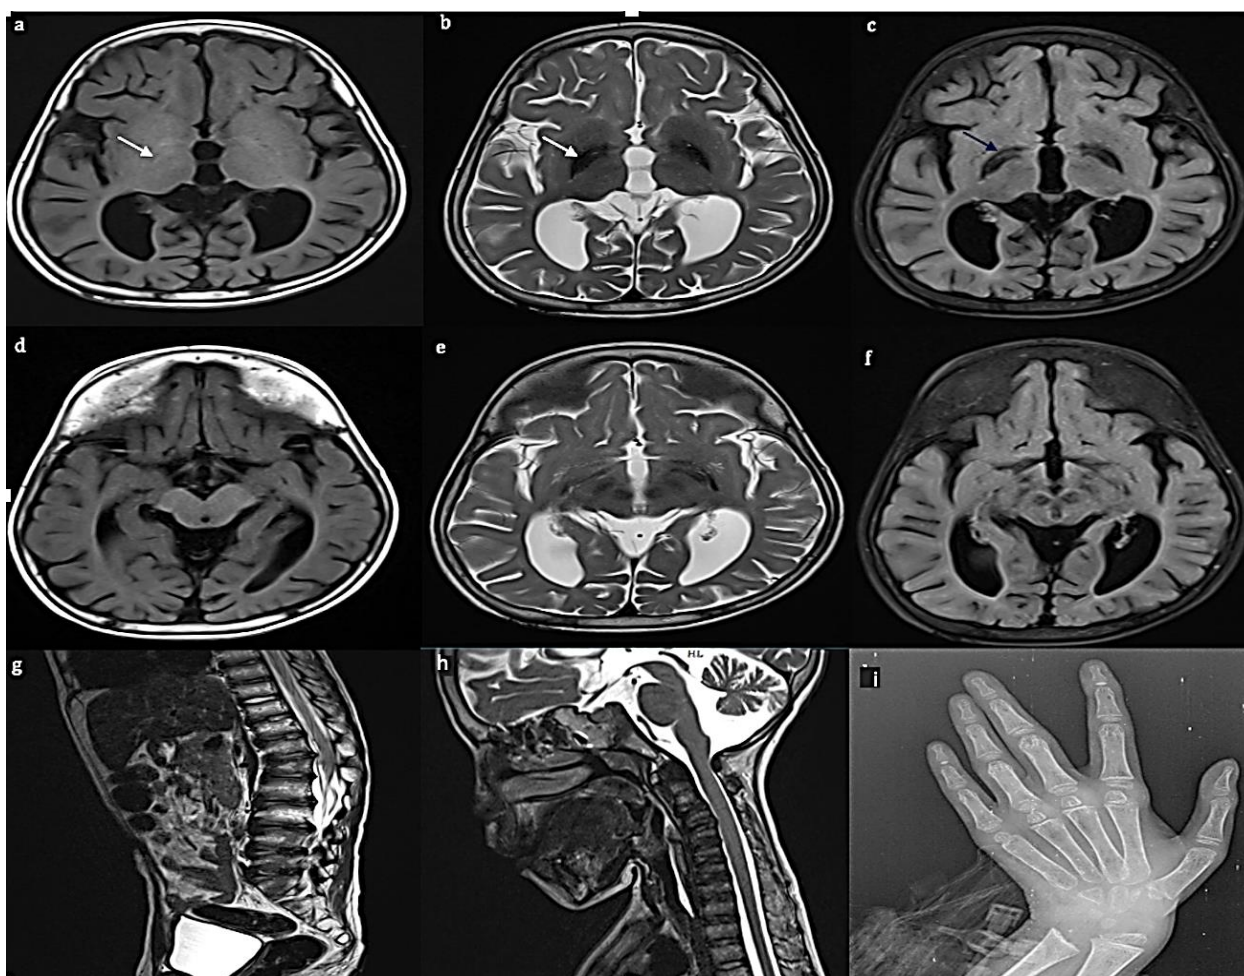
Axial brain T1 magnetic resonance imaging (MRI) (a), T2 (b), and fluid-attenuated inversion recovery (FLAIR) (c) images at the level of basal ganglia showing bilateral globus pallidus appearing hyperintense on T1-weighted imaging (T1WI), markedly hypointense on T2-weighted imaging (T2WI) (marked by white arrow) and FLAIR. There is curvilinear hyperintensity within basal ganglia on T2 and FLAIR images (marked by blue arrow). There is associated prominence of cortical sulci and ventricles which represents generalized cerebral atrophy; axial brain T1 MRI (d), T2 (e), and FLAIR (f) images at the level of mid brain showing substantia nigra and red nuclei appearing hypointense on T2WI and FLAIR (marked by white arrow); sagittal dorsolumbar spine T2 MRI (g) image showing platyspondyly with anterior beaking at L3-L5 vertebral levels; sagittal cervical spine T2 MRI (h) image showing reduced vertebral body heights of C3 to C7 vertebrae with hypoplastic odontoid process; posteroanterior (PA) view of wrist radiograph (i) showing delayed ossification of carpal bones and mild proximal tapering of metacarpals
